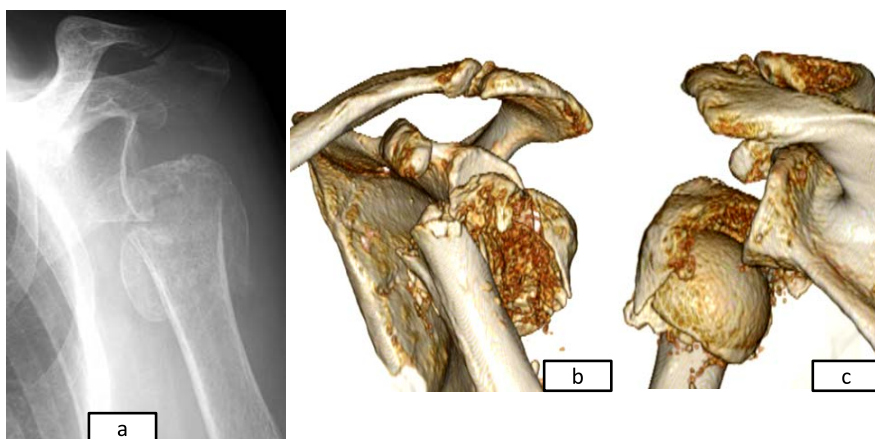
Case 2 : radiographic images
